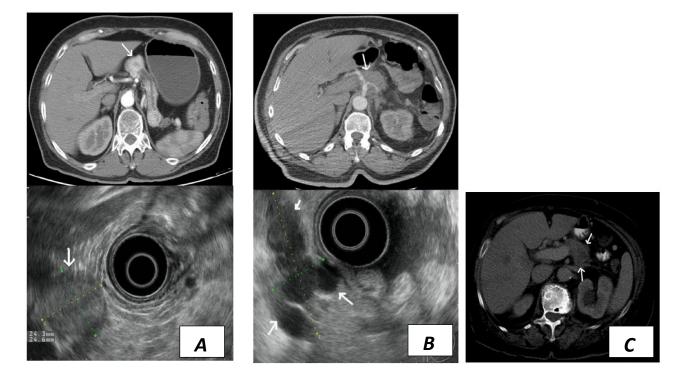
A) CT and EUS findings of case 1. A near 30 mm solid lesion in the head of the pancreas was revealed (arrows). B) CT and EUS findings of case 2. An inhomogeneous, about 80 mm in size hypodense mass was seen on CT with calcification in the tail and the peripancreatic area was moderately infiltrated. C) CT finding of case 3. An 56 x 31 x 43 mm hypodensity (arrows) was revealed with multiple liver metastases.
